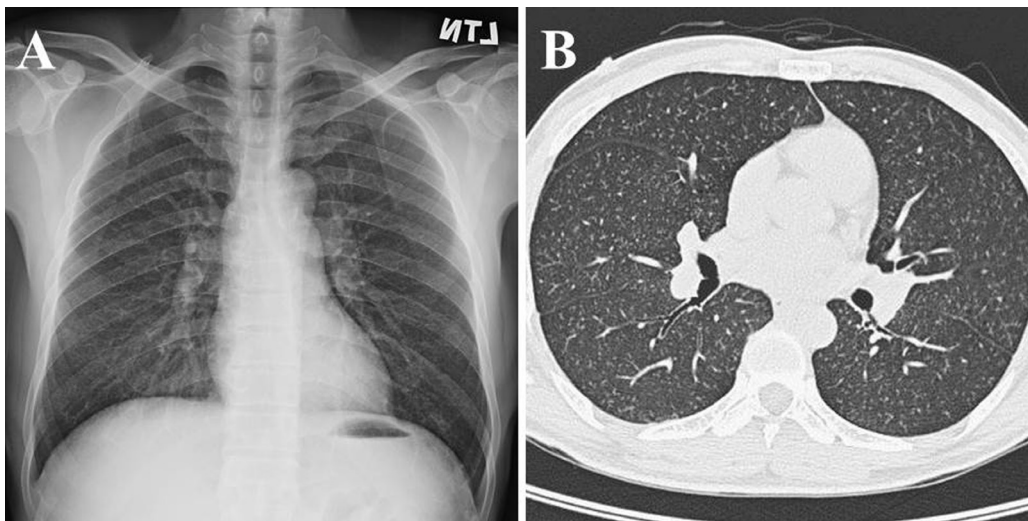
(A).Chest radiography revealed diffuse micronodular lesions. (B). High resolution computed tomography showed diffuse randomized tiny 1-3 mm nodules.
